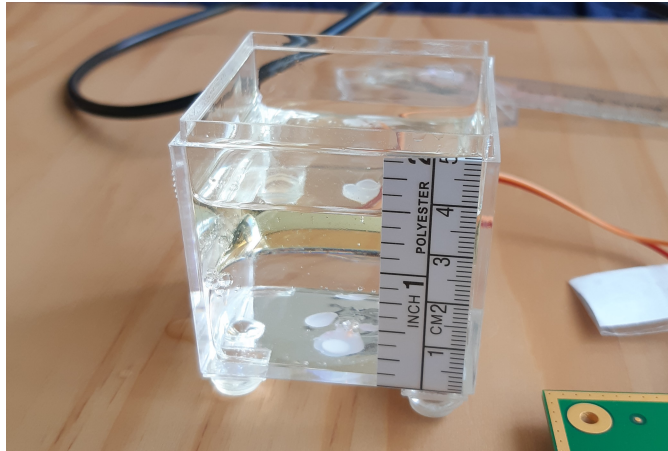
Acrylic container with an attached ultrasound transducer at the bottom.
